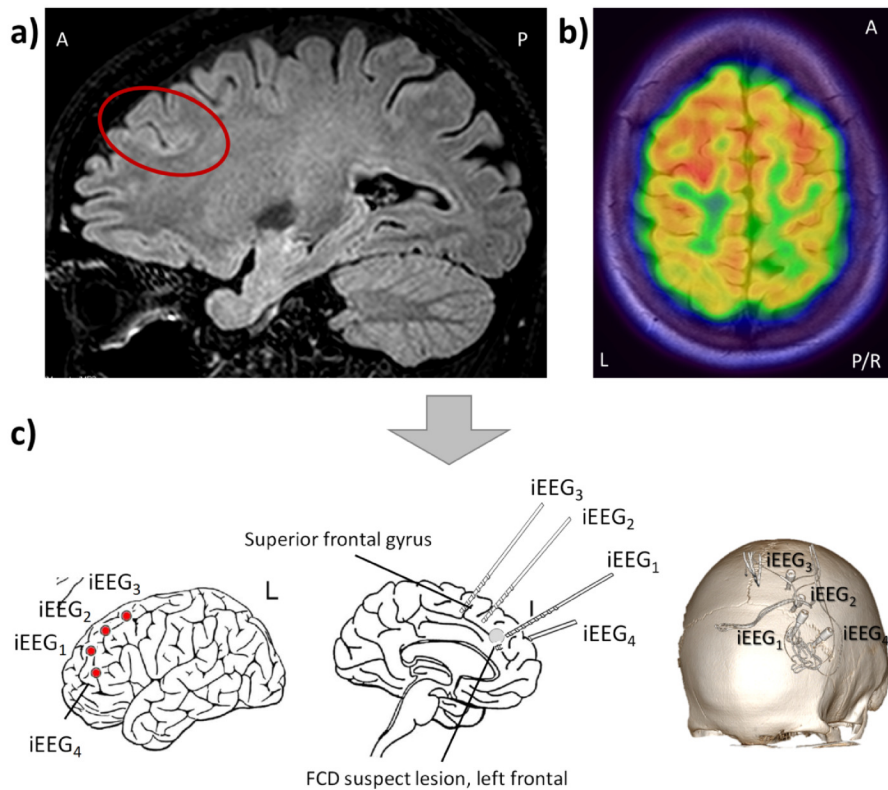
Results of non-invasive presurgical workup and planning of the invasive EEG study: a) a sagittal view of the 3D-FLAIR MRI at that time which was reported as normal, but with a suspicious, unusually deep sulcus in the middle frontal gyrus (area in red circle); b) hypometabolism in the left superior frontal gyrus on fluorodeoxyglucose positron emission tomography (FDG-PET), suggesting a possible functional deficit zone; c) depth electrode placement for the invasive video EEG study (electrodes named iEEG₁, iEEG₂, iEEG₃ and iEEG₄). The electrodes were implanted into the suspicious deep sulcus and the left superior frontal gyrus. Abbreviations Anterior (A), Posterior (P), Left (L) and Right (R) declare orientation.
